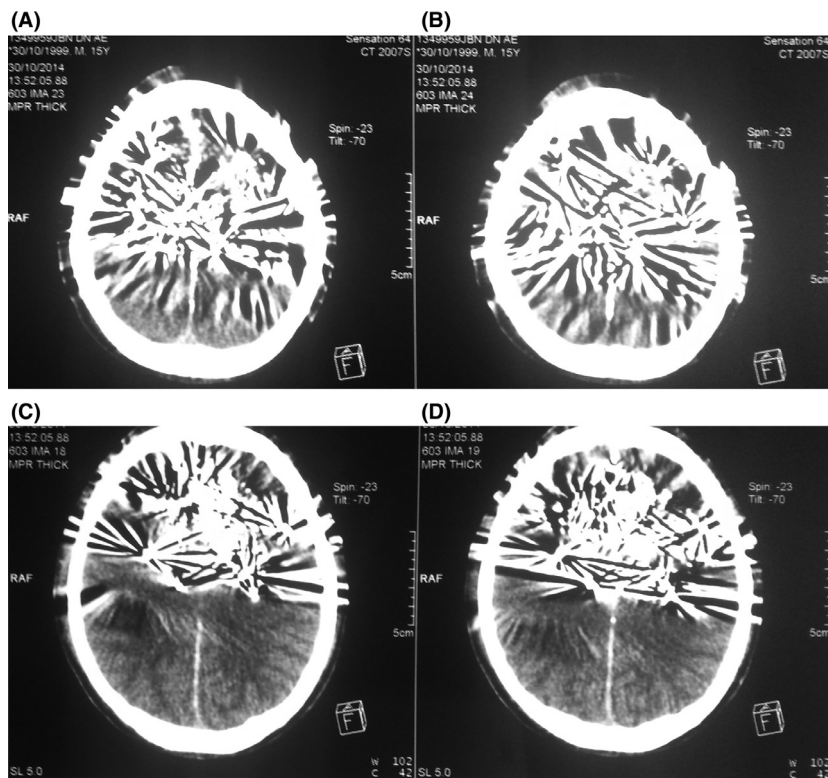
(A–D) Computed tomography of the brain showed pellets from the bullet in the frontal, parietal, and temporal lobes.
